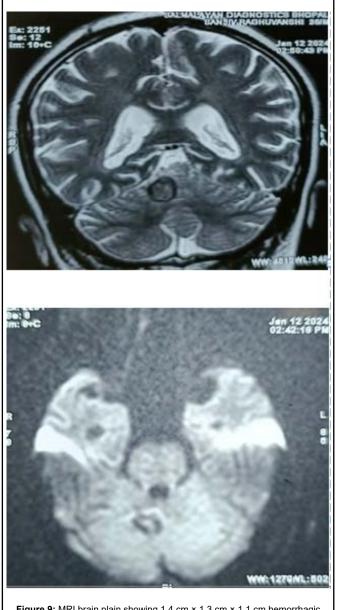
MRI brain plain showing 1.4 cm  $\times$  1.3 cm  $\times$  1.1 cm hemorrhagic metastatic lesion in right cerebellum.
